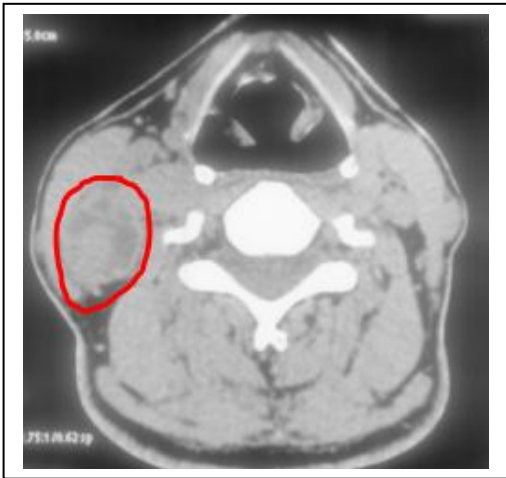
CT image of a Partial responder showing right level II node
